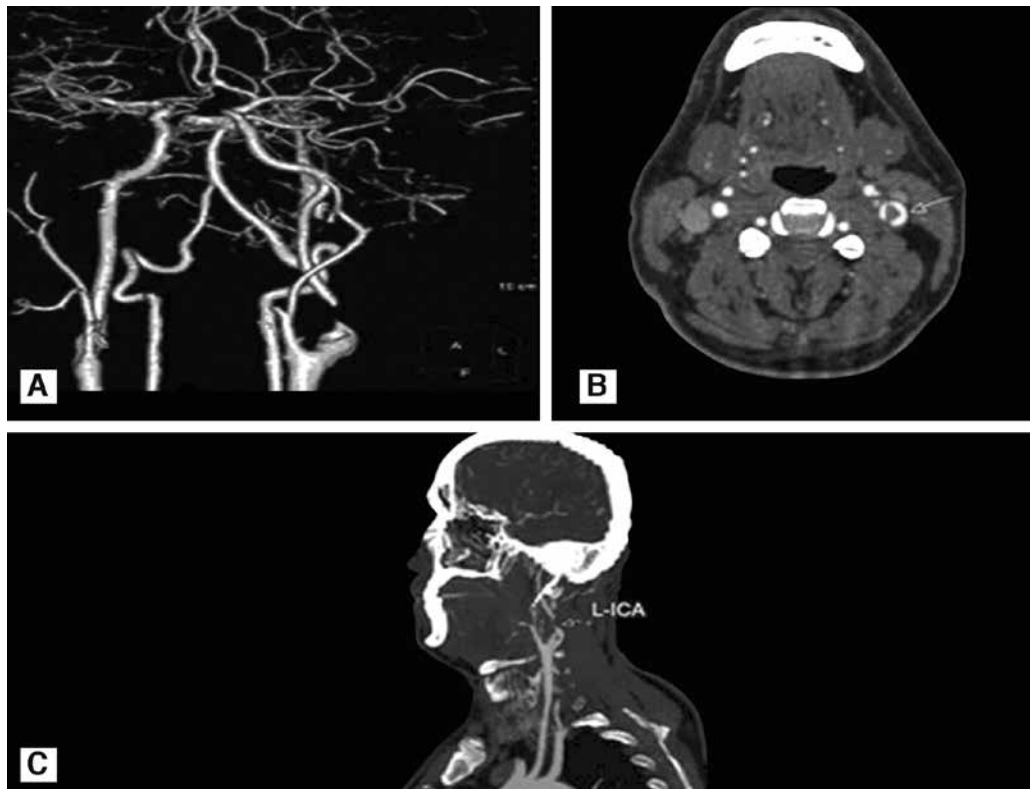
A) Dissection of the left internal carotid artery as shown by 3-dimensional computed tomography angiography, B) Intraluminal thrombus of the left internal carotid artery demonstrated on a transvers computed tomography-image (arrow), C) Sagittal reconstructed maximum intensity projection scan showed intraluminal thrombus of the left internal carotid artery (arrow)
